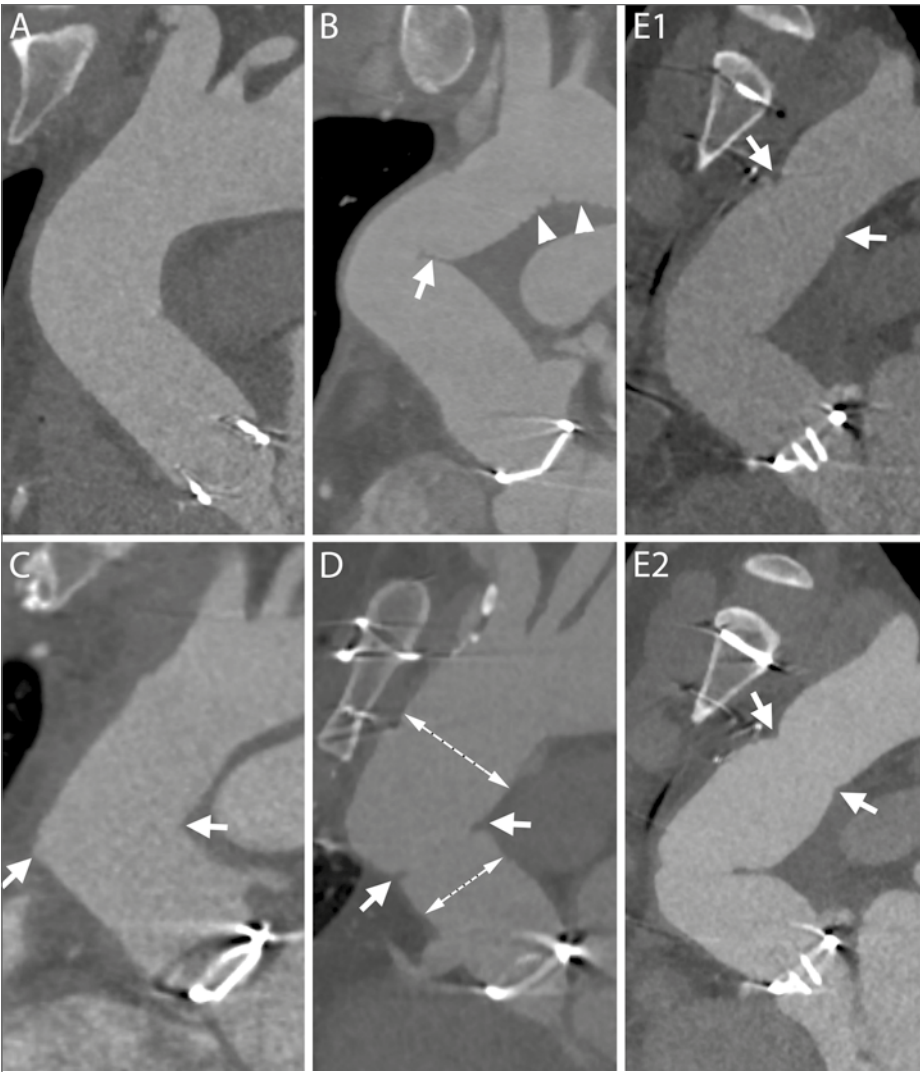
Normal aspect of aortic grafts. A – The aortic graft can present a smooth outer contour and appear similar to a native aorta. B – Especially in case of a sharp angulation of the ascending aorta and in case a long graft has been employed, the fabric of the graft can present an inward fold projecting inside the aortic lumen (arrow). The small grooves of the outer surface of the graft can also be visible on CT scans (arrowheads). C – When two grafts are employed, a sharp angle in the contour of the ascending aorta may develop at the level of the connection (arrows). D – If needed for anatomical reasons, the two employed grafts can have different sizes (two dashed lines) and a slight inward fold is seen at the level of the suture (arrows). E1-E2 – Two consecutive scans of the same patient, acquired within less than one year, show a change in angulation and appearance of the aortic grafts. The distal suture of the more caudal of the grafts with the native aorta is evident as it appears as a stricture in the aortic contour (E1-E2, arrows).
